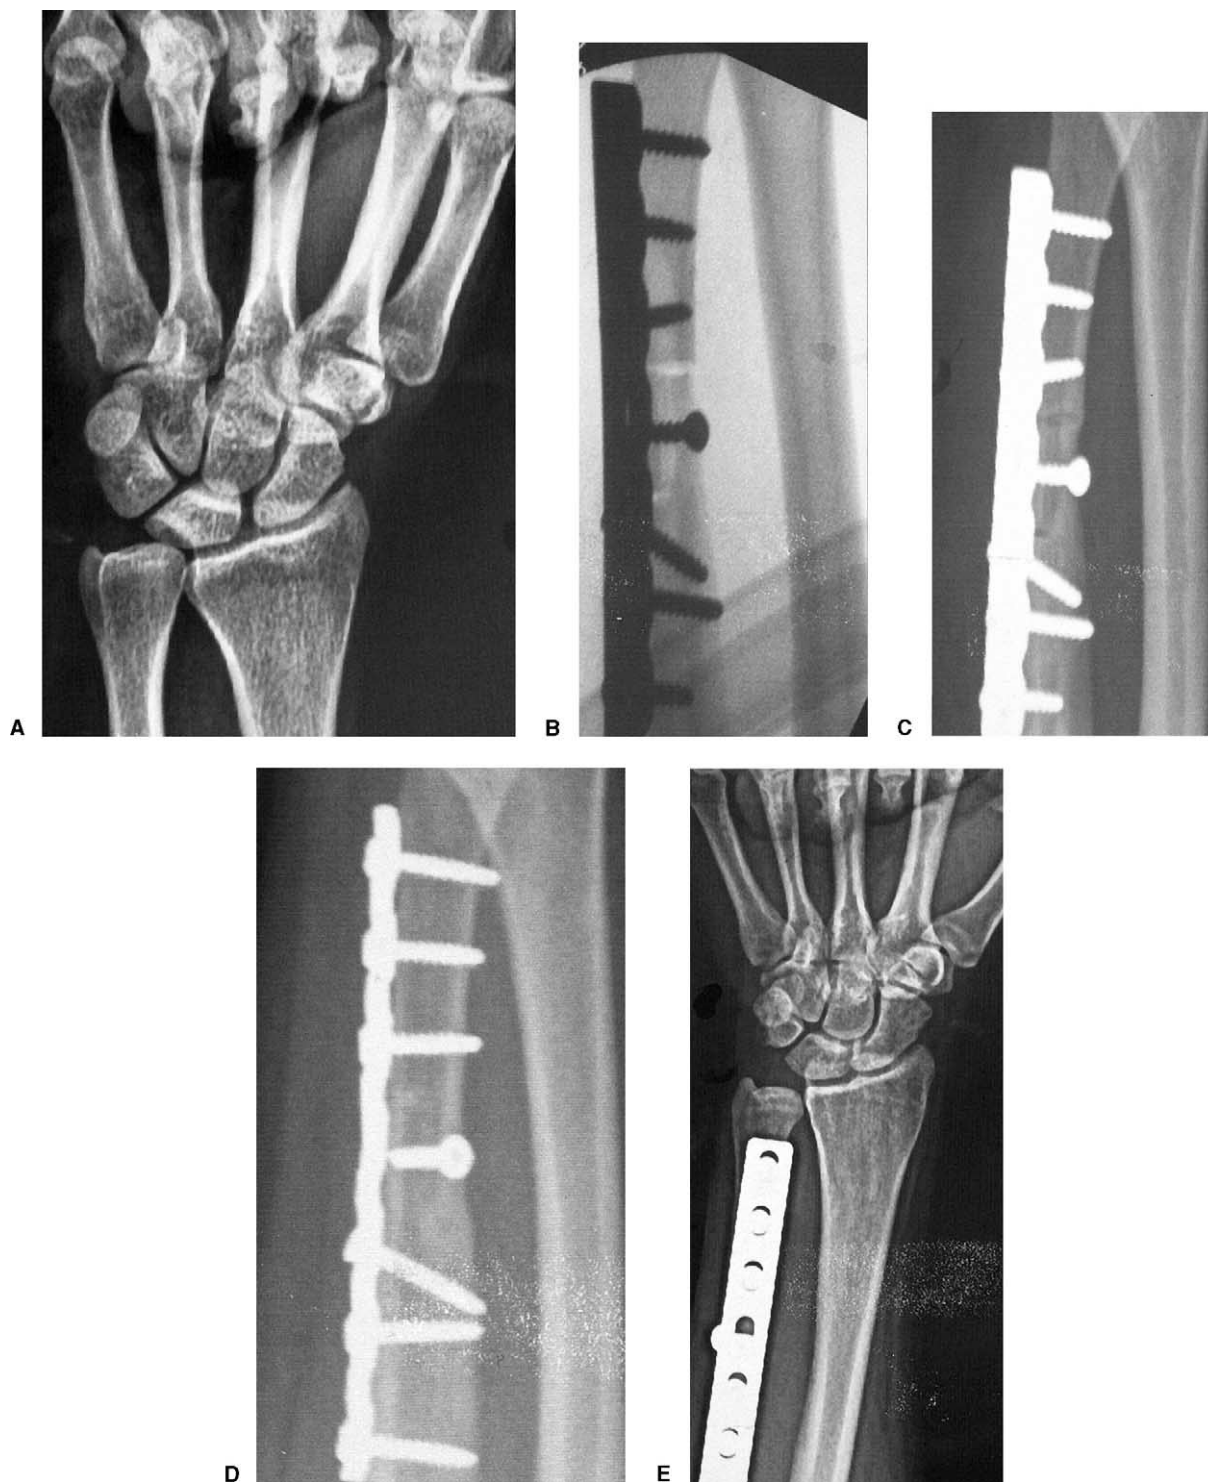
(A) Preoperative pronated grip view radiograph of a patient with ulnocarpal impaction. The cystic kissing lesion at the ulnar side of the lunate can be observed. Progression of healing of the step-cut osteotomy on oblique-view radiographs of the same patient: (B) intraoperative, (C) at 6 weeks, and (D) at 10 weeks. (E) Postoperative pronated grip-view radiographs showing correction of ulnar variance.
